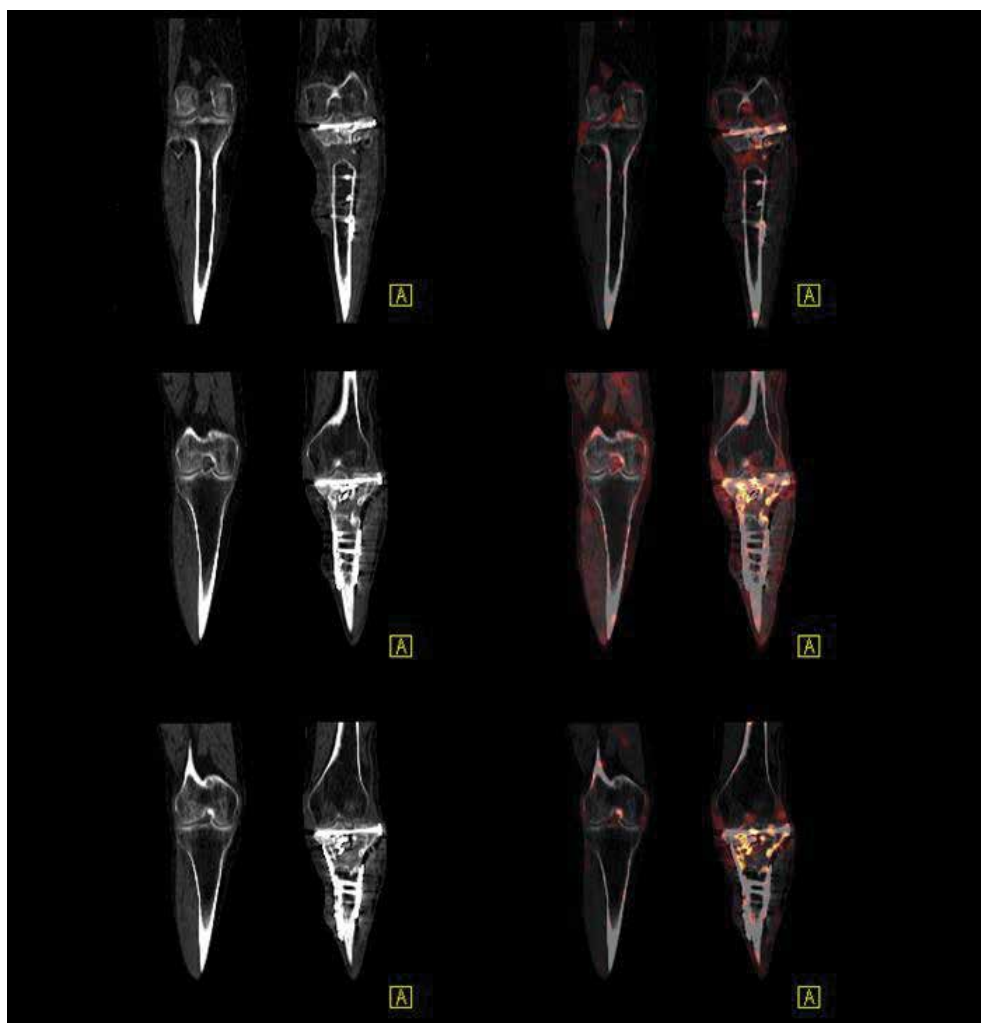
Coronal CT and fused SPECT/CT slices demonstrate the extent of accumulation of ^{99m}Tc -labelled antigranulocyte antibodies within the tibial plateau, fracture fragments and internal fixation plates—which suggests an active infection.
